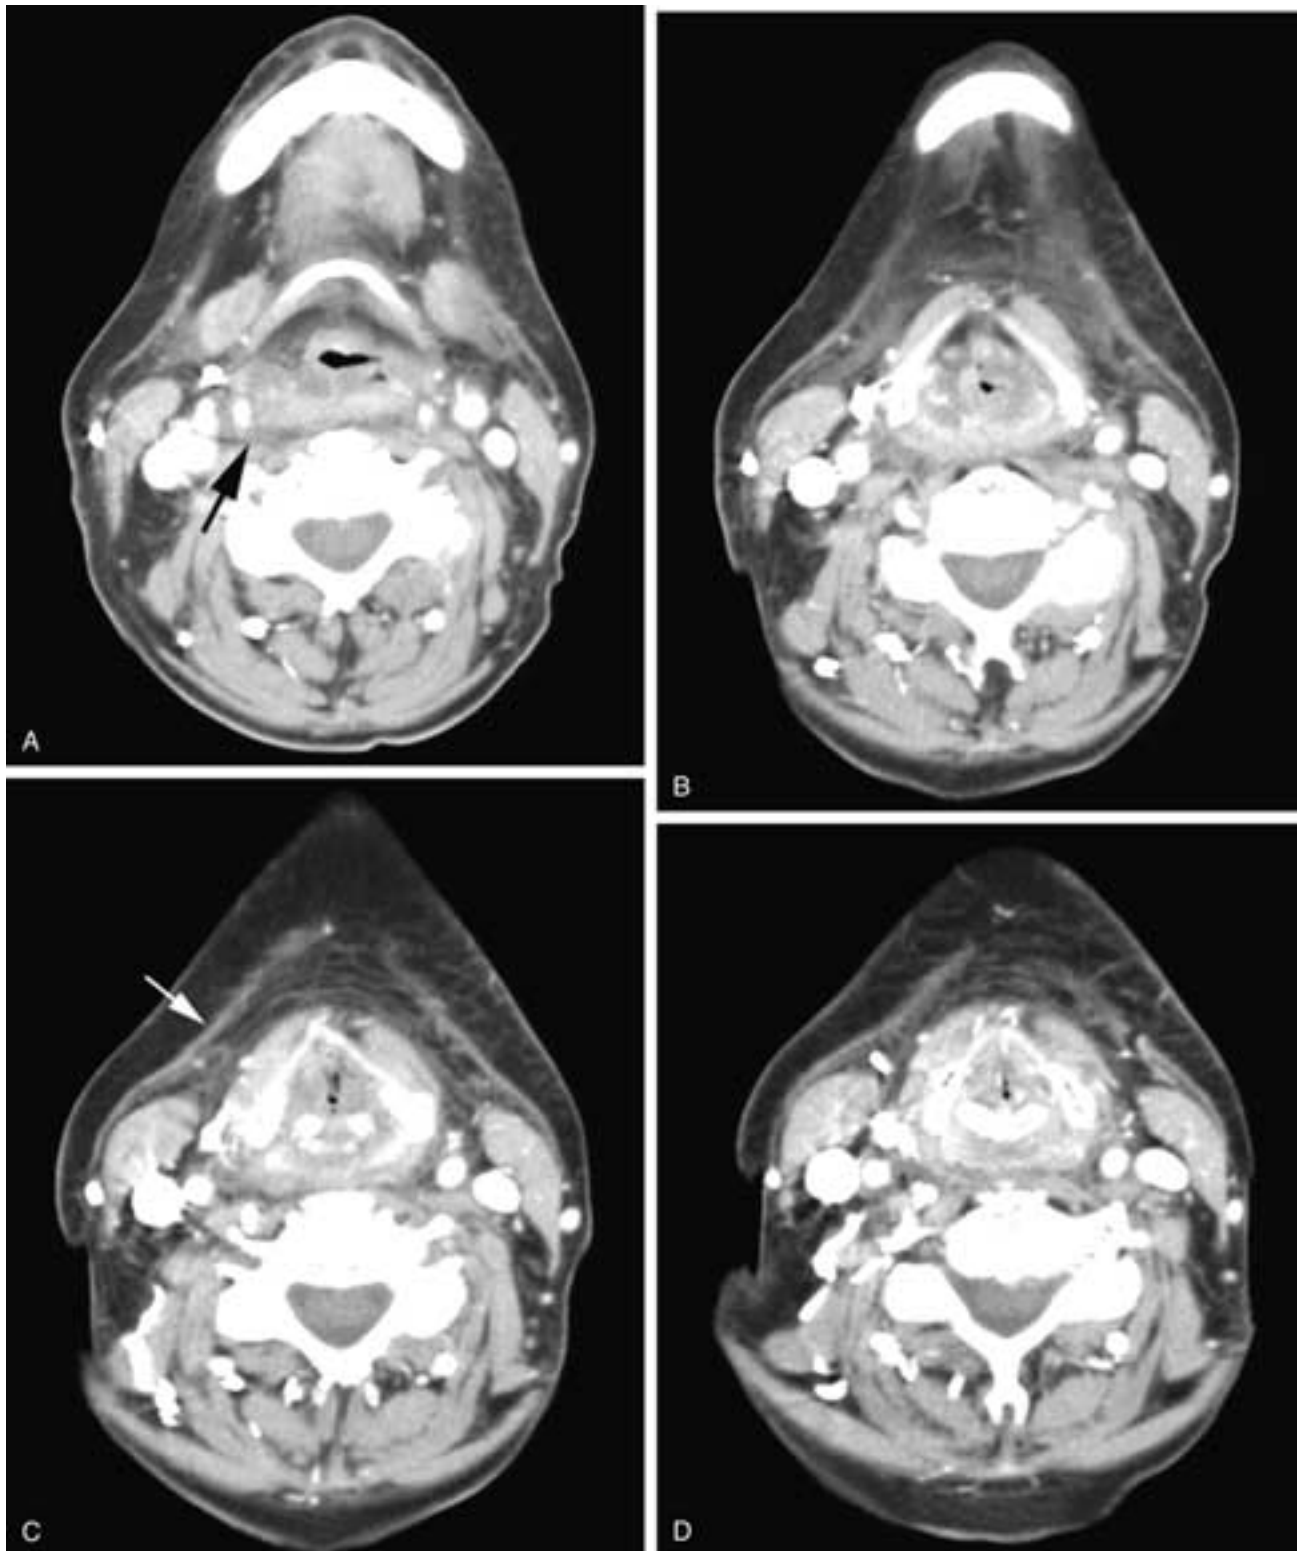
Serial axial contrast-enhanced CT scan from cranial (A) to caudal (D) in a patient who received RT to the neck. There is marked thickening of the mucosal surfaces, not only in the supraglottic larynx (A and B) but also in the glottic (C) and subglottic (D) larynx. This is a more pronounced reaction than normal (see Fig. 43-10). Note that the attenuation of the supraglottic laryngeal soft tissues is less than that of muscle, suggesting that it represents edema. Also note the retropharyngeal edema (arrow in A) usually seen in irradiated patients (see Fig. 43-10). In addition, there are edematous, inflammatory-type changes in the superficial subcutaneous fat with thickening of the platysma (arrow in C). Despite the apparent airway narrowing on imaging, many of these patients have no dyspnea.
